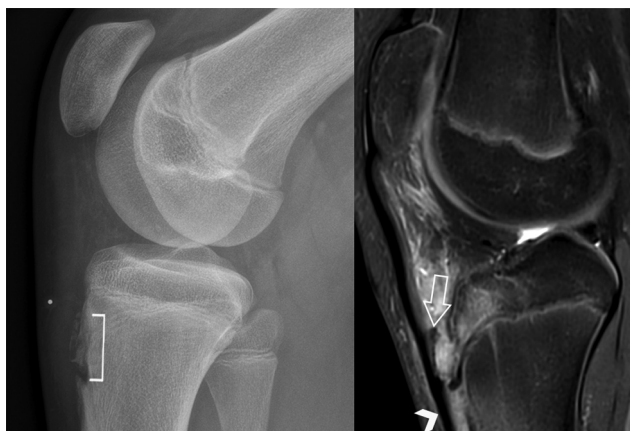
Tibial tuberosity avulsion fracture. Lateral radiograph (left) from a 12-year-old boy shows irregularity and fragmentation of the anterior distal tibial tuberosity (bracket) and overlying soft tissue swelling that underlie the skin marker (dot). Sagittal T2-weighted fat-suppressed MR (right) image, obtained 2 weeks later for worsening pain, shows a linear avulsed fragment (block arrow), underlying the patellar tendon and distal periosteal stripping (chevron).
